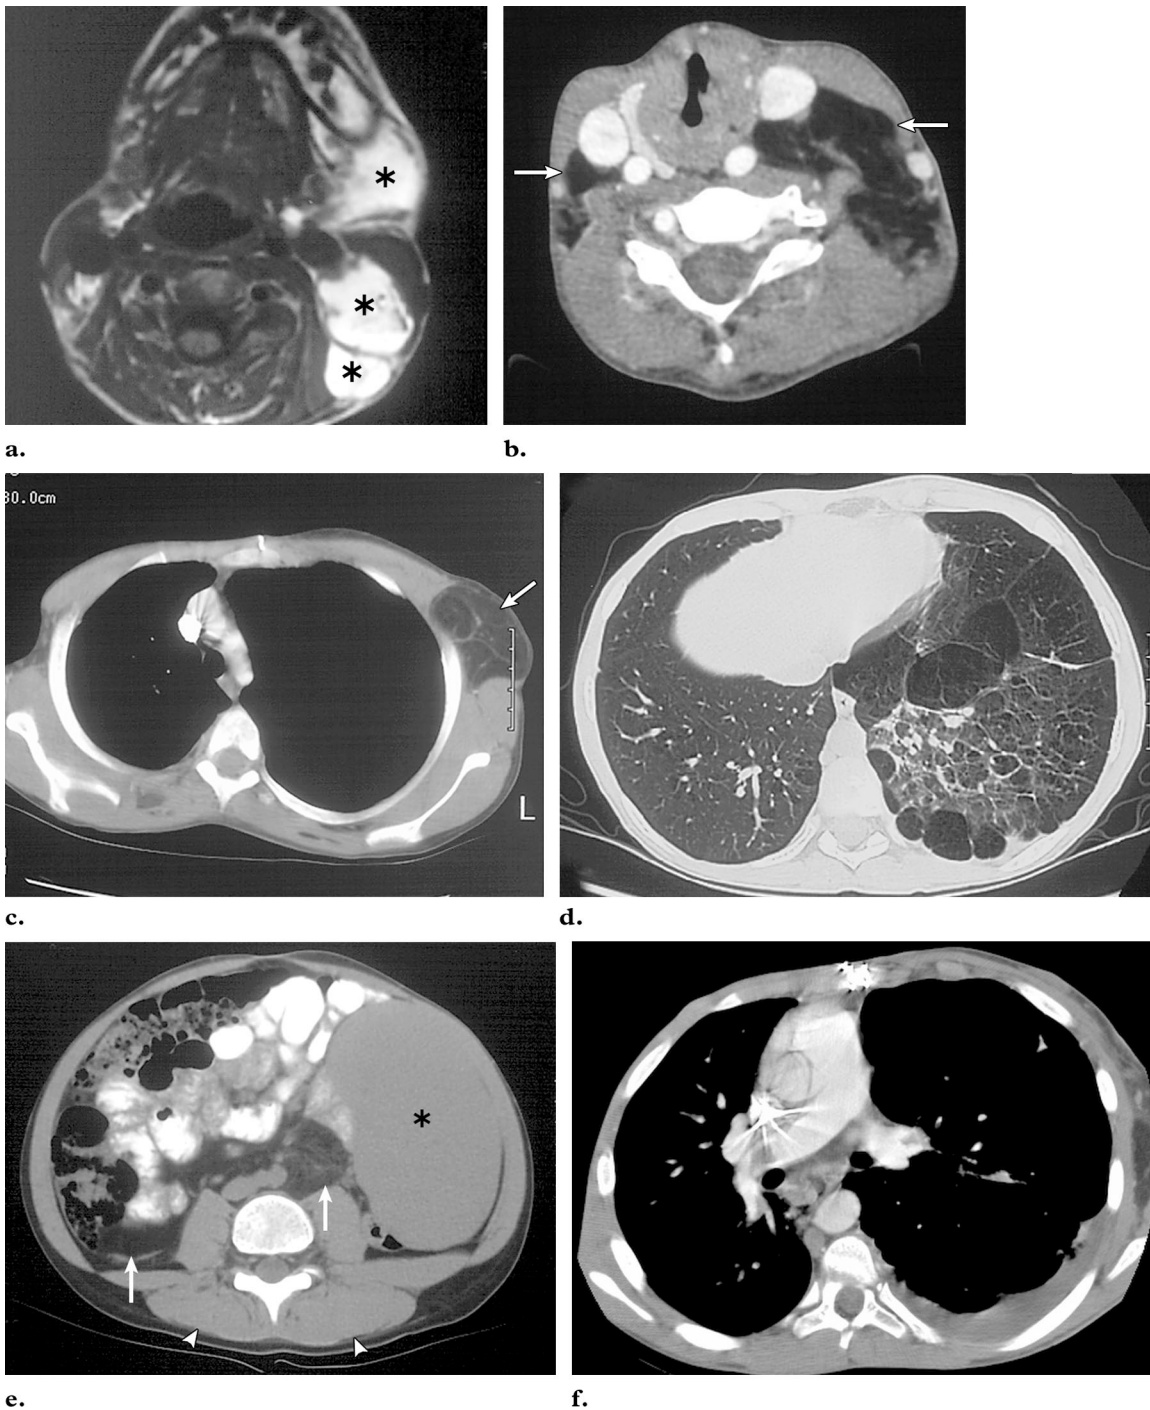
Lipomas, splenomegaly, cystic lung changes, and pulmonary embolism. (a) Axial T1-weighted MR image obtained in a patient aged 11 years at the level of the mandible shows asymmetric fatty masses (*) anterior to, and under, the sternocleidomastoid muscles, a finding more prominent in the left side than the right. (b) Axial CT image obtained at a level below a, in the neck, shows multiple bilateral asymmetric masses with the attenuation of fat (arrows), more prominent in the left side than the right, and causing deviation of the midline structures in the neck to the right. (c) Axial CT image at the level of the upper thorax shows asymmetric overgrowth of fat in the anterior thoracic wall, a focal fatty lesion in the left axilla (arrow), deviation of the mediastinum to the right, and asymmetry of the thorax, with the left hemithorax larger than the right. (d) Axial CT image at the level of the lower thorax depicts hyperexpansion of the left lung and areas of severe scarring and cystic changes in the left lower lobe, as well as mild cystic changes in the right lower lobe. (e) Axial CT image of the abdomen shows increased retroperitoneal fat (arrows); asymmetric development of the paraspinal muscles (arrowheads), with the left side greater than the right; and marked splenomegaly (*). (f) Contrast-enhanced CT image of the chest obtained 4 years later shows filling defects in the lower lobes of the right and left lungs because of emboli in the pulmonary arteries, as well as a small left pleural effusion.
